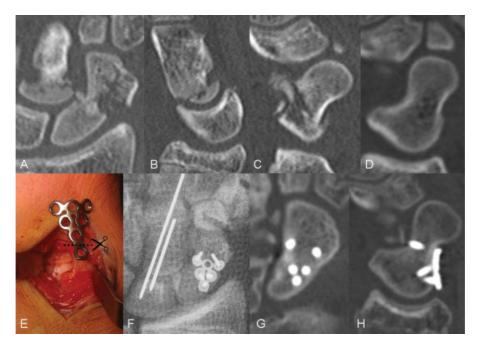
(A-C) Coronal and sagittal CT images of the transscapho-transcapitate fracture dislocation including a comminuted scaphoid waist fracture and proximal capitate fracture with limited palmar rotation of the fragment. (D) Sagittal CT image of the contralateral healthy scaphoid. (E) Surgical exposure of the scaphoid fracture site through a palmar ligament-splitting approach. The plate was cut to the appropriate length, and bent to conform to the contour of the palmar scaphoid surface. (F) Postoperative anteroposterior radiograph showing two K-wires and plate in situ. (G, H) Postoperative coronal and sagittal CT image of the fixated scaphoid showing consolidation and anatomic alignment. CT, computed tomographic.
